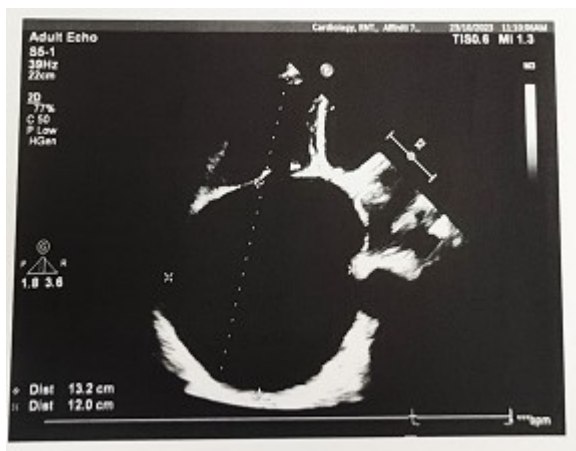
Echocardiography of Right atrium showing abnormality dilated 13\*12 cm size
